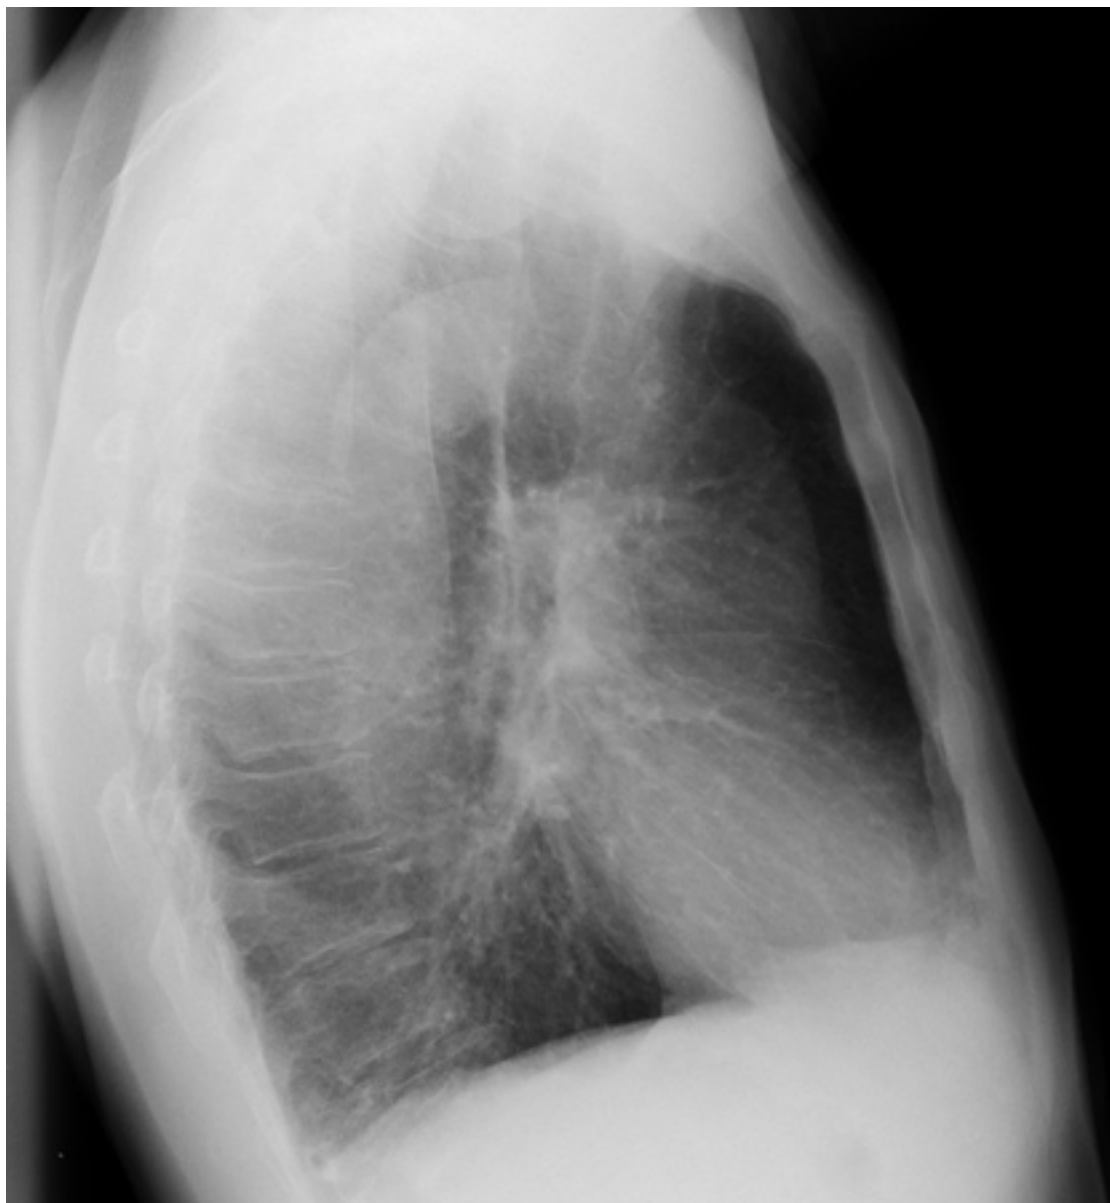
COPD chest x-ray (lateral view): hyperinflated lung, flattened diaphragm, increased antero-posterior diameter (barrel chest) in lateral view
